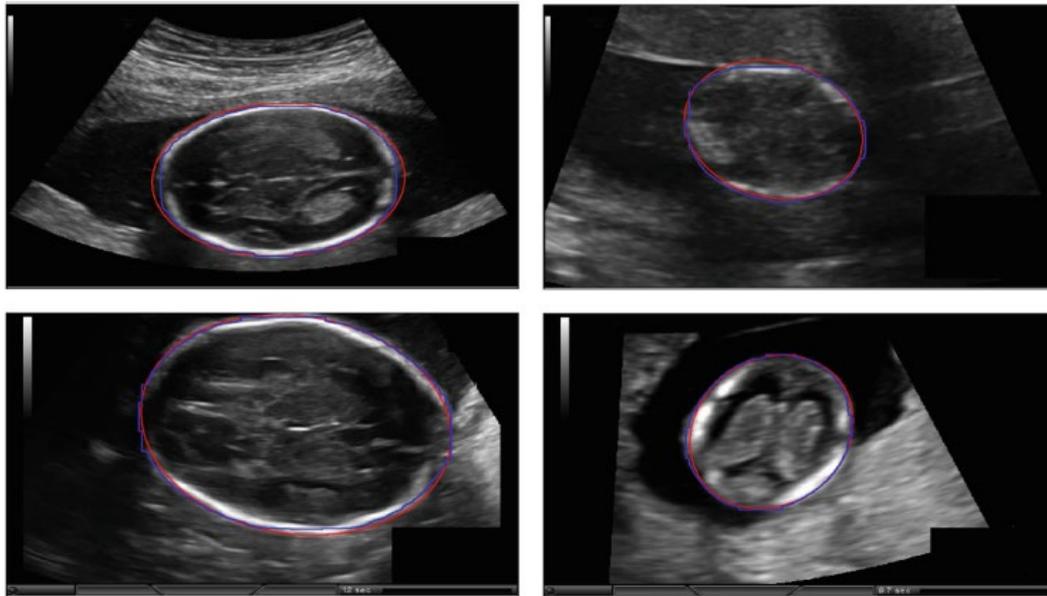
Examples of fetal head segmentation showing the ellipse fitted results on the two-dimensional ultrasound sections.
